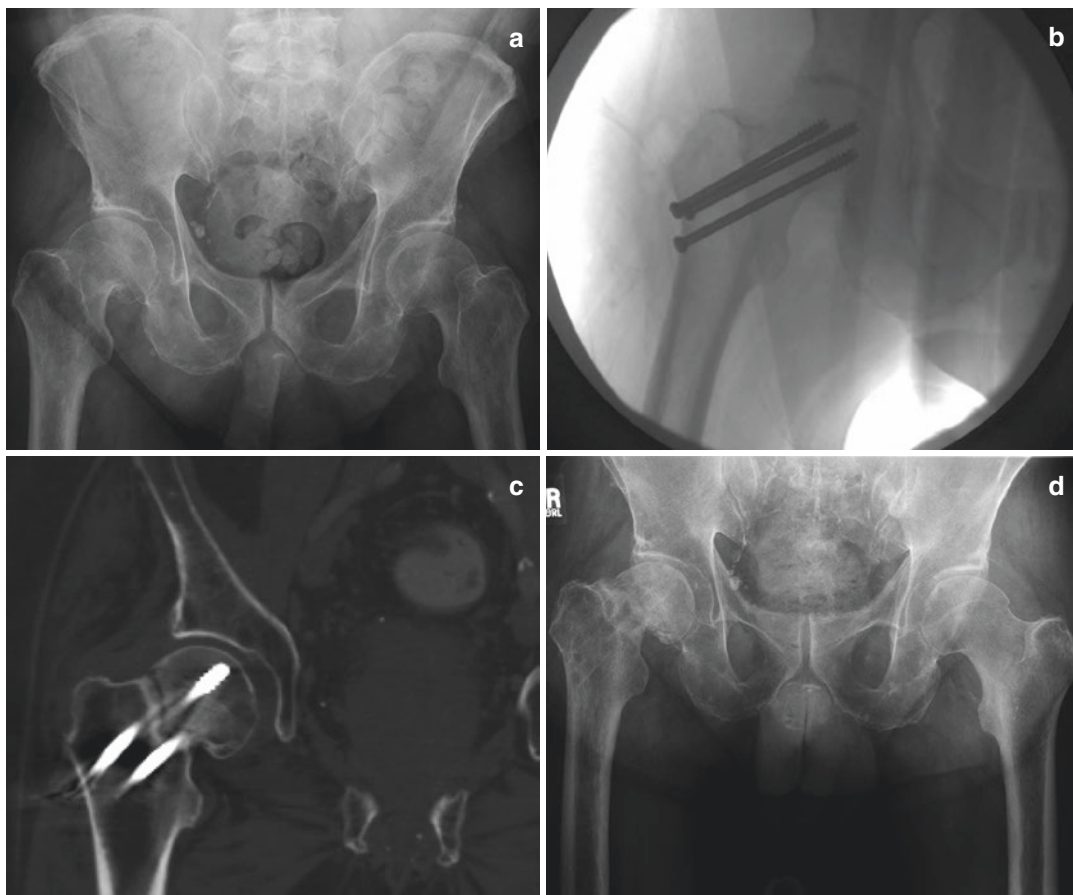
(a) AP pelvis radiograph demonstrating a right subcapital femoral neck fracture. The patient was subsequently treated with three partially threaded 7.3 mm cannulated screws in an inverted triangle configuration. (b) AP intraoperative fluoroscopic image demonstrating final hardware placement. The patient eventually returned to independent ambulation with a cane. However, he had continued right hip pain, which was attributed to trochanteric bursitis from screw prominence. Sixteen months later the patient received a CT scan for evaluation of abdominal pain that noted an “incompletely healed femoral neck fracture”. (c) Coronal CT image 16 months after initial fixation. A vertically oriented nonunion with sclerotic margins is present. The patient was taken to surgery 1 month later for removal of his “symptomatic hardware” in the setting of presumed trochanteric bursitis. The treating physician was unaware of the CT scan demonstrating nonunion. A metabolic work-up was not obtained prior to his second right hip surgery. The patient followed up in clinic 1 week later where he was noted to have significant displacement of his femoral neck nonunion. (d) AP radiograph demonstrating a displaced
